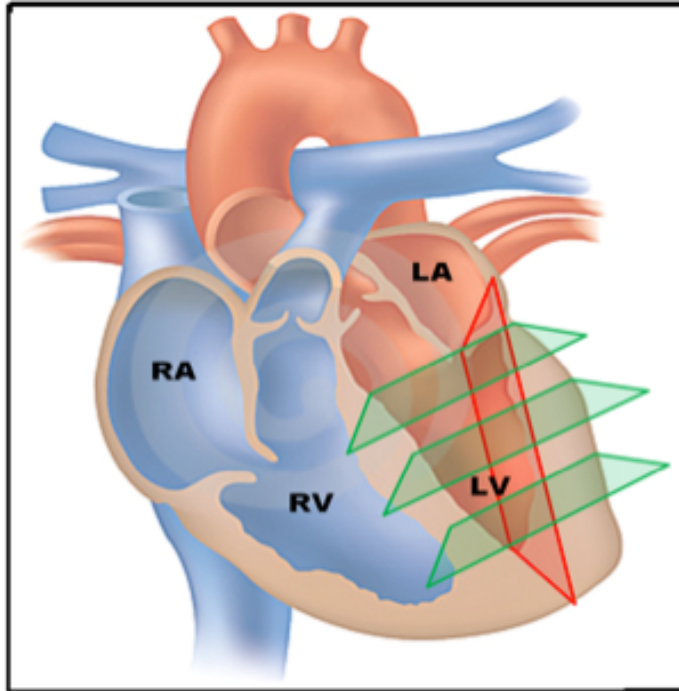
Variation in sample volume location using 2D Doppler. The red plane shows the variation in long axis direction and the green planes show short-axis variation in sample volume location.
